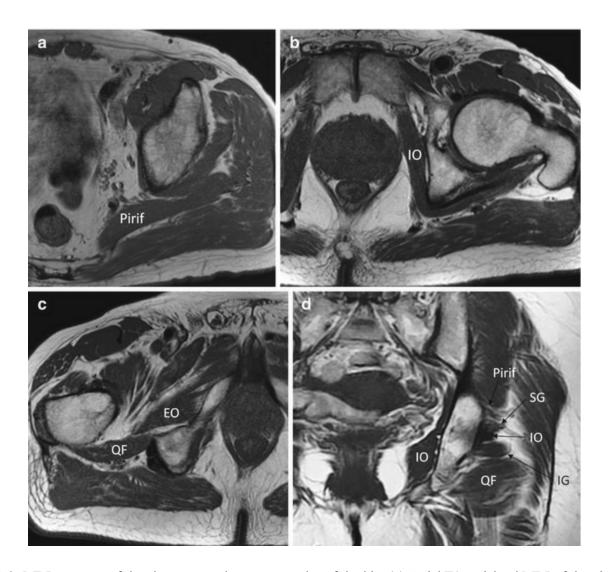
MRI anatomy of the short external rotator muscles of the hip. (a) Axial T1-weighted MRI of the piriformis muscle (Pirif.), (b) the internal obturator (IO), (c) and the quadratus femoris muscle (QF) and external obturator (EO), (d) Coronal T1-weighted MRI of all the previous muscles (except the external obturator) but also of the inferior and superior gemellus muscles (IG and SG)
